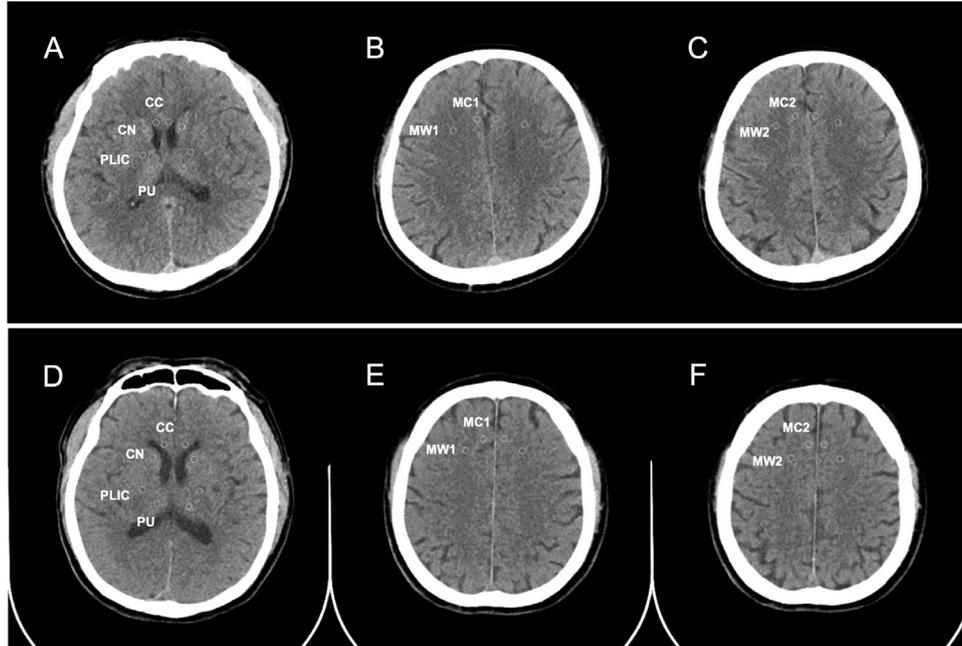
Grey-white matter ratio (GWR) measured using early unenhanced brain computed tomography in patients with good and poor neurological outcomes.
